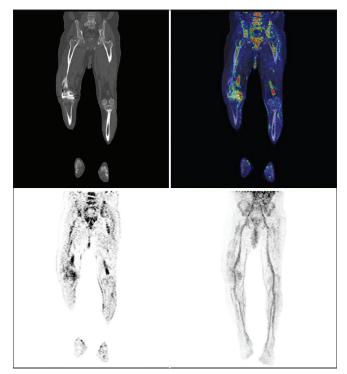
Views of coronal section of both thighs from a Ga-68 citrate positron emission tomography-computed tomography scan. (Top left) computed tomography: Metal implant in the right distal femur with fracture; (top right) Fused positron emission tomography-computed tomography: Avid infectious focus in the right distal femur; (below left) positron emission tomography: Avid infectious focus in the right distal femur; (below right) maximum intensity projection image: physiological uptake with the focus of increased tracer activity in the right distal thigh
